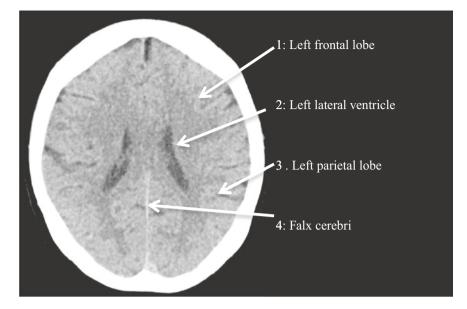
Axial non-contrast CT brain
